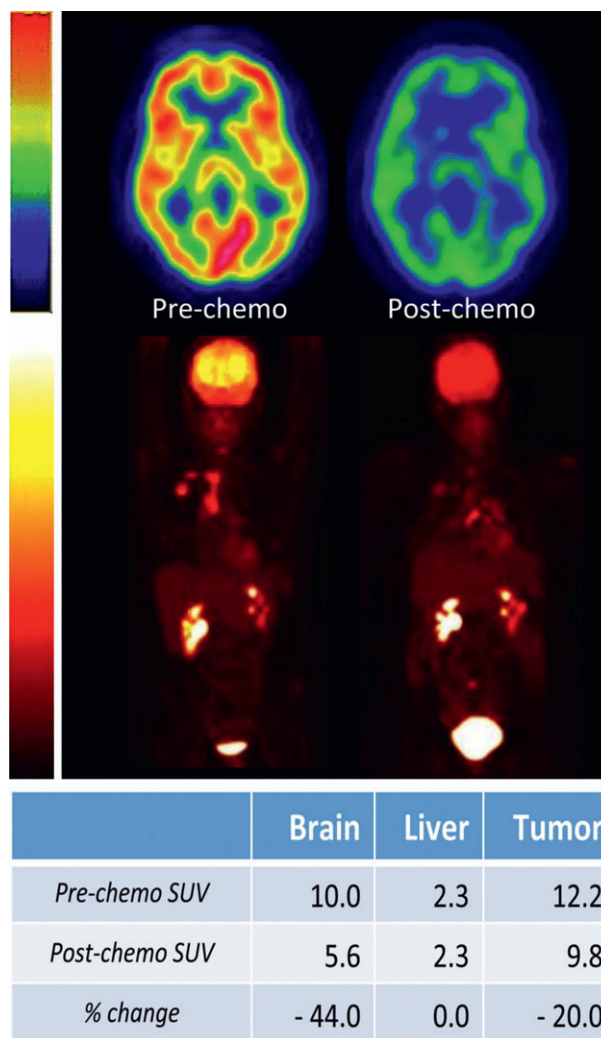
Alterations of resting state glucose metabolism prior to and after chemotherapy. Top panel: axial brain images in a representative patient (subject #10, see Table 3), demonstrating normal resting brain metabolism on the "pre-chemo" image and a reduction by 44% in the "post-chemo" image (SUV_{max} decreases from 10.0 to 5.6). In this "rainbow" color display, the areas with highest glucose metabolism are shown as orange to red. Areas with lowest glucose metabolism are shown as green to blue. Lower panel: maximum intensity projection PET images of the head through the thighs in the same patient showing the change in resting whole-body metabolism between baseline (prechemotherapy) and follow-up (post chemotherapy) imaging. In "hot lava" color display, high metabolism is indicated by yellow to white colors and low metabolism is indicated by red and black. The tumor in the right lung demonstrates a higher metabolism at baseline and lower metabolism on follow-up, compatible with a reduction in tumor size and favorable response to treatment (SUV_{max} decreases from 12.2 to 9.8, a decrease by 20%). In the liver, serving as a control organ, the values for SUV_{max} do not change between baseline and follow-up, demonstrating consistency in technique. As an additional finding on both image sets, physiologic radiotracer excretion is seen in kidneys and bladder. PET, positron emission tomography; SUV, standardized uptake value.
